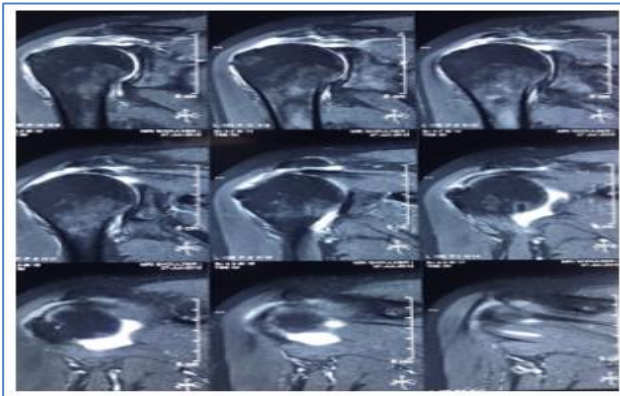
Coronal sections of MRI showing supraspinatus tear.
